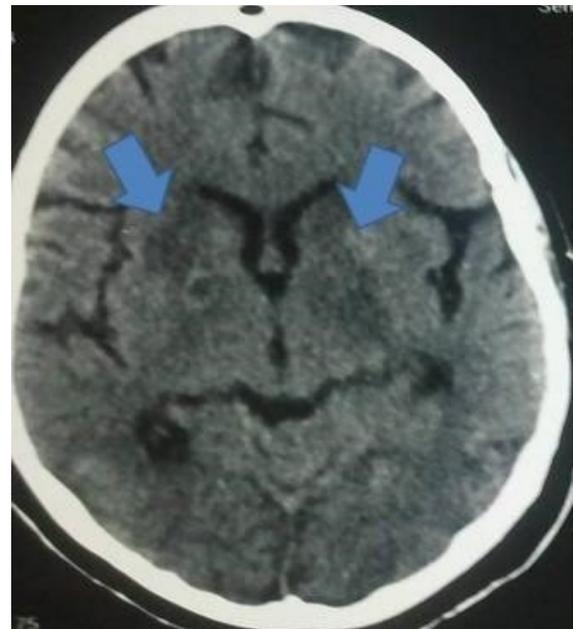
Cranial CT, day 30, bilateral deep white-matter lesions to continue as sequel changes.
